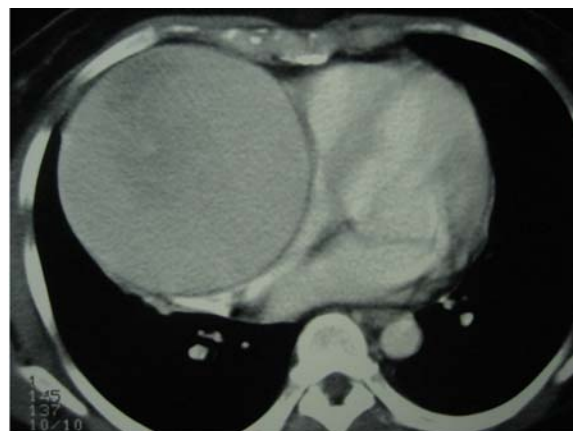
CT scan and TTE revealed a vascular mass with compression affecting distal SVC and RA
